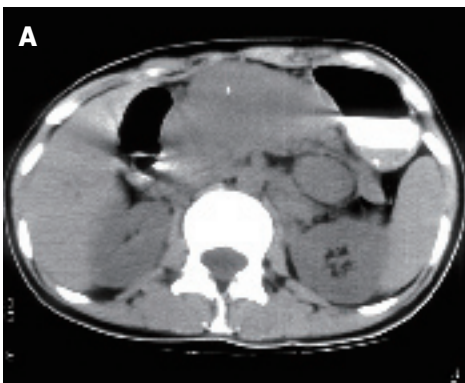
A: Plain CT showing a uniform density, slightly lobular tumor (formed by multiple enlarged lymph nodes) in the lesser omentum; B: The tumor having a notable shrinkage in size and flecked calcifications found within the tumor after treatment on plain CT.
